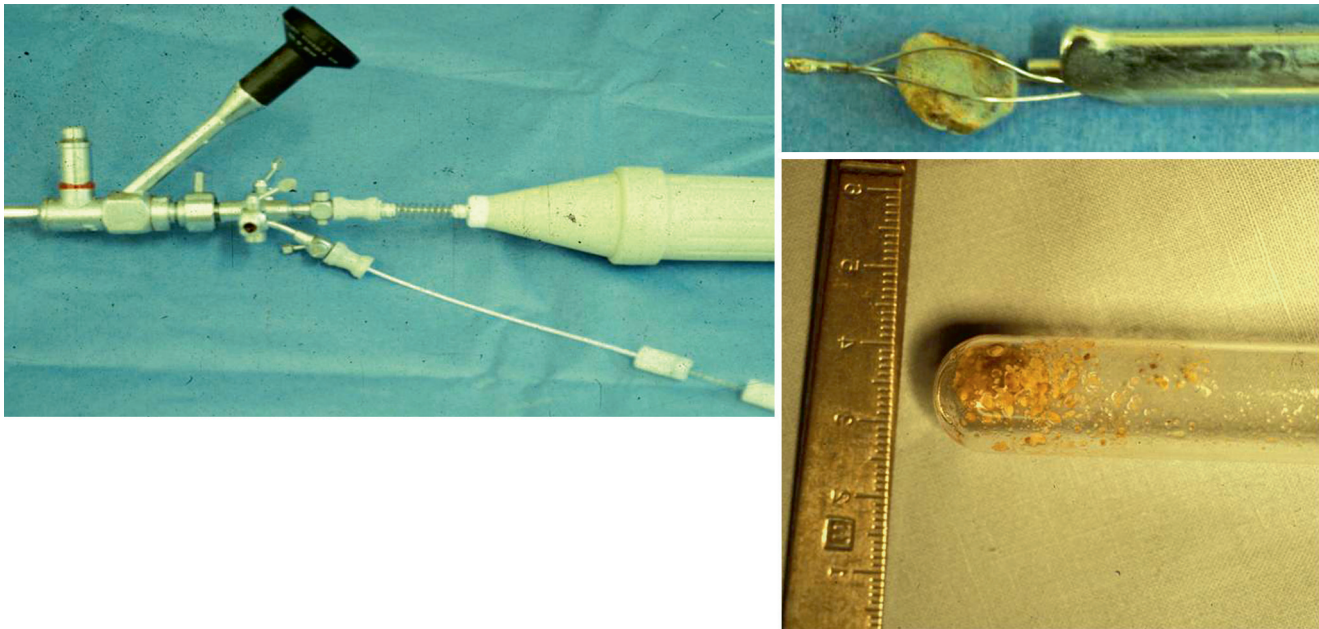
The offset ureteroscope allows direct ultrasonic lithotripsy under vision. The probe is placed onto the stone and activated to fragment it. Although the probe is small, tiny fragments could be removed
